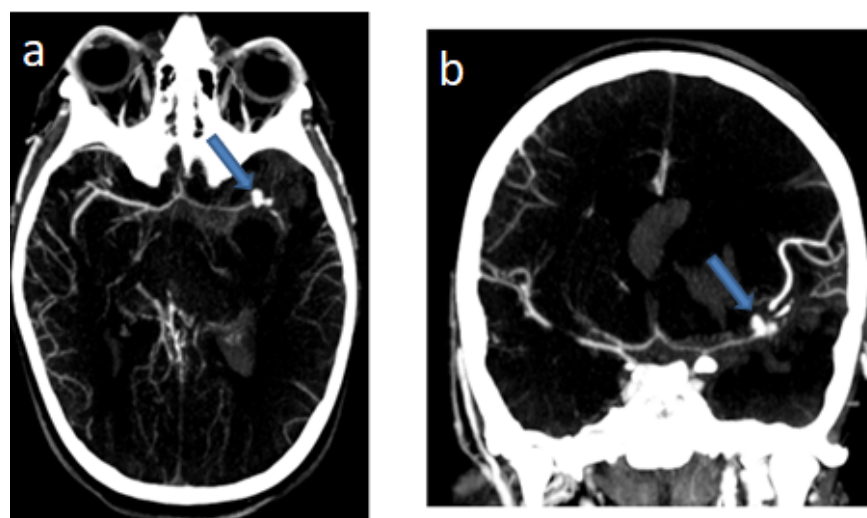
cerebral CT arteriography , axial plane (a) and reconstruction in the frontal plane with MINMIP (b) showing a saccular aneurysm of the left sylvian artery (arrow)
